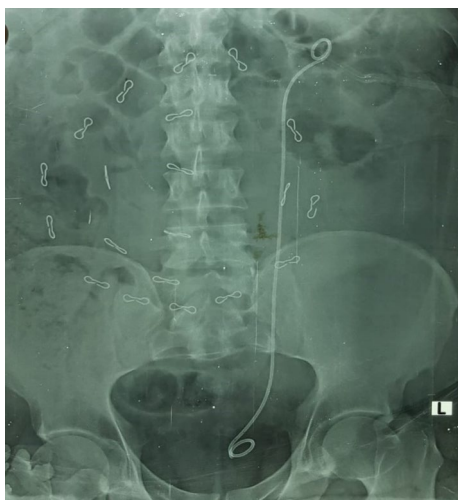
The final plain X-ray demonstrated new left double J
